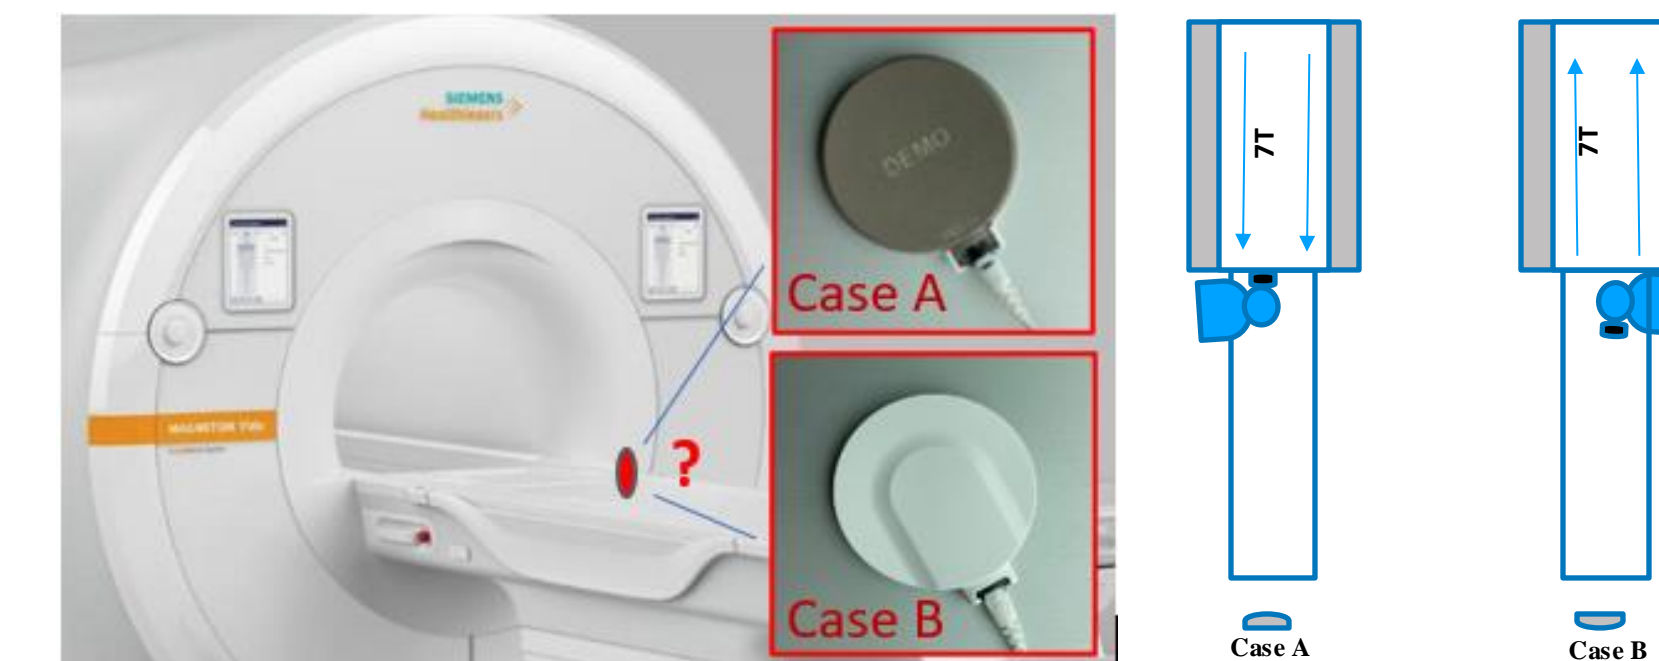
The two possible orientations of the axial AP-coil when exposed to the static magnetic field of the MRI scanner. Positions close to the opening of a 7.0T MRI scanner for re-magnetizing a CI magnet, depending on the orientation of the static magnetic field of the scanner
